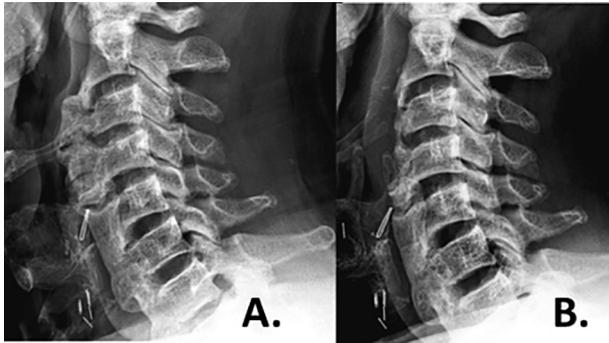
Lateral X-rays of the cervical spine.
